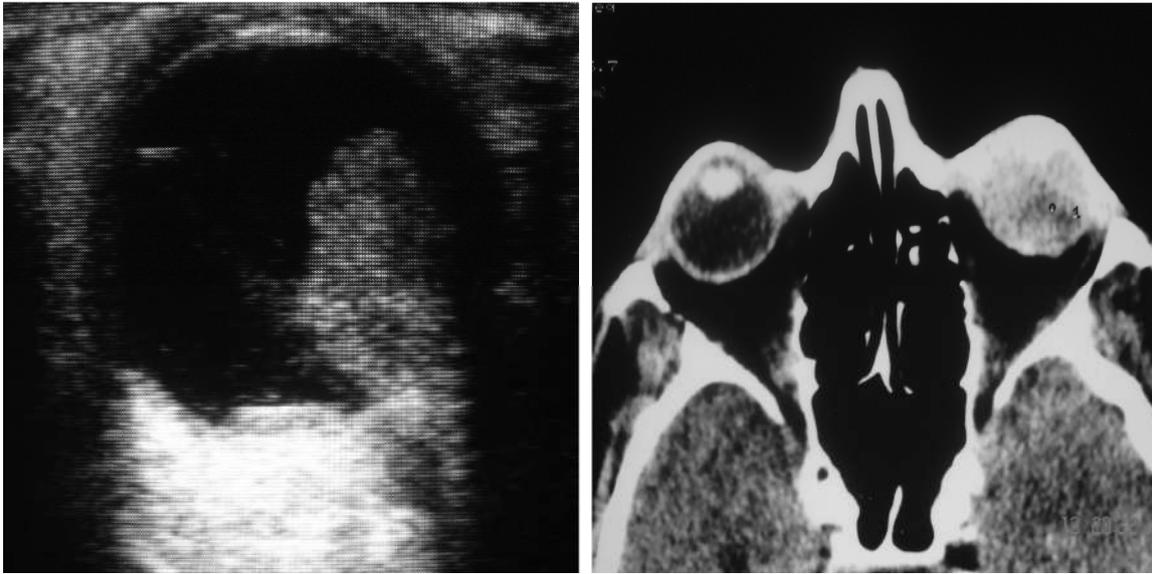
Choroidal melanoma- Eccentric lobulated intraocular soft tissue mass lesion with vitreous hemorrhage appearing hyperdense on CT (right)
